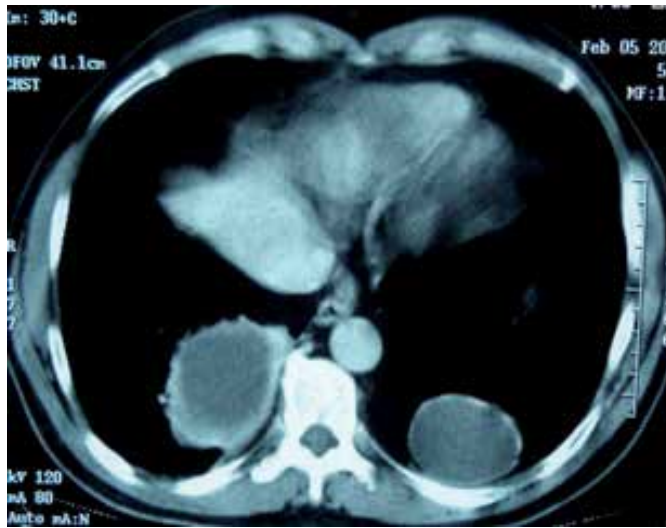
CT scan showing two well-circumscribed homogenous cysts over right and left lower lobes
